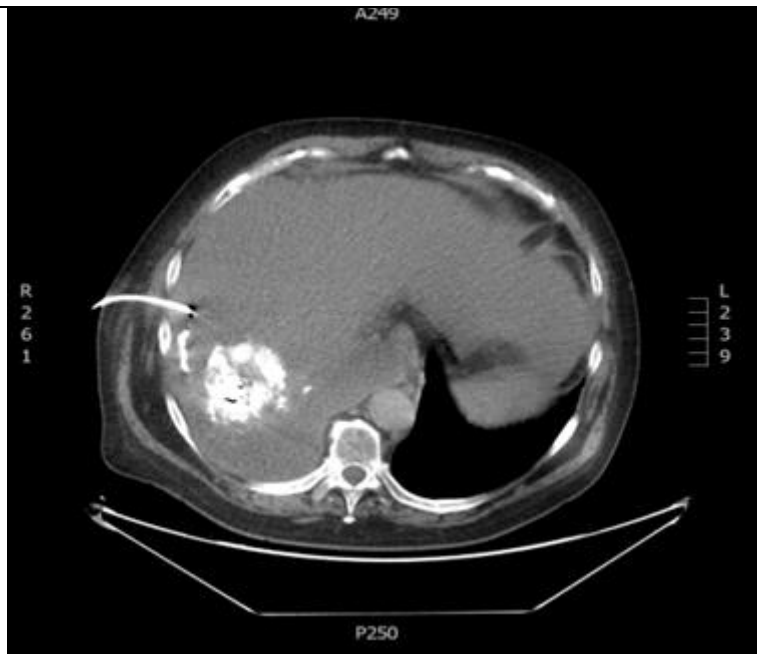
Percutaneous CT-guided drainage.
